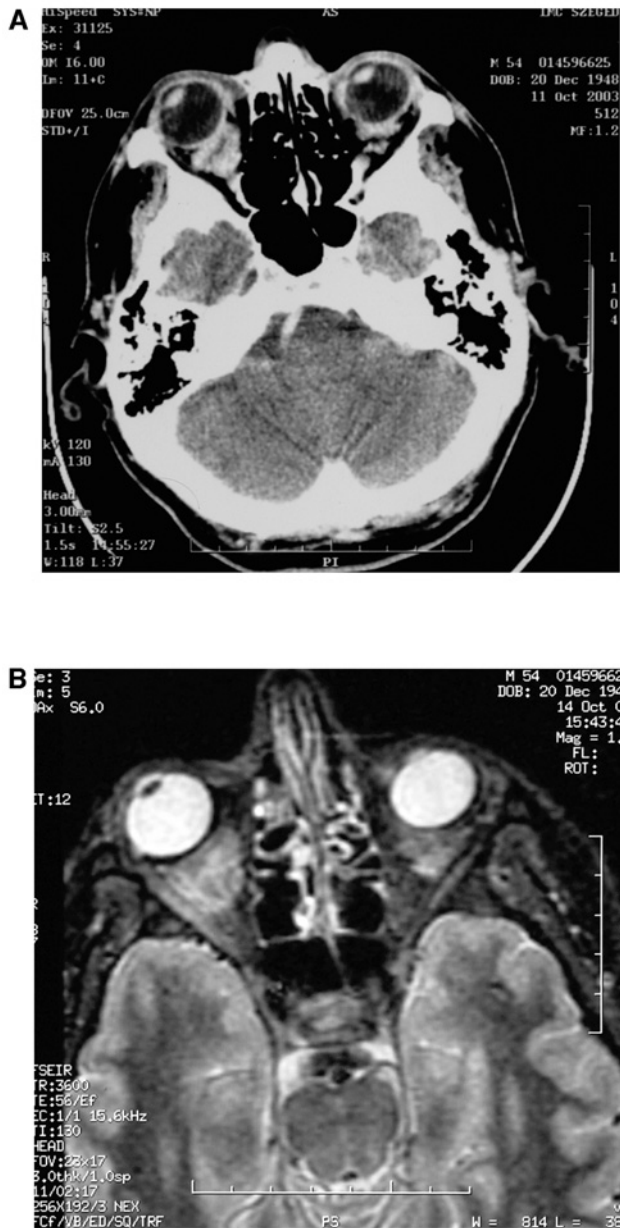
Radiological evaluation of the exophthalmos. CT (A) and MRI (B) scans show retrobulbar mass in both orbits.
